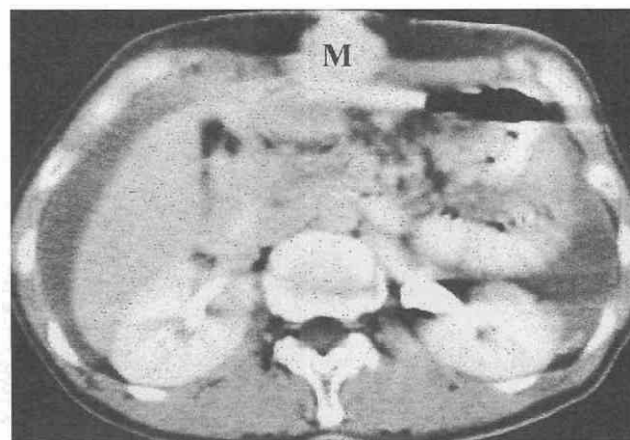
Tumor recurrence at the incisional wound after surgery for gastric cancer. CT scan shows a lobulated, well-enhancing mass (M) along the incisional wound as well as a large amount of ascites and peritoneal thickening due to peritoneal carcinomatosis. (From Ha HK, Kim HH, Kim HS, et al: Local recurrence after surgery for gastric carcinoma: CT findings. *AJR Am J Roentgenol* 161:975-977, 1993.)
